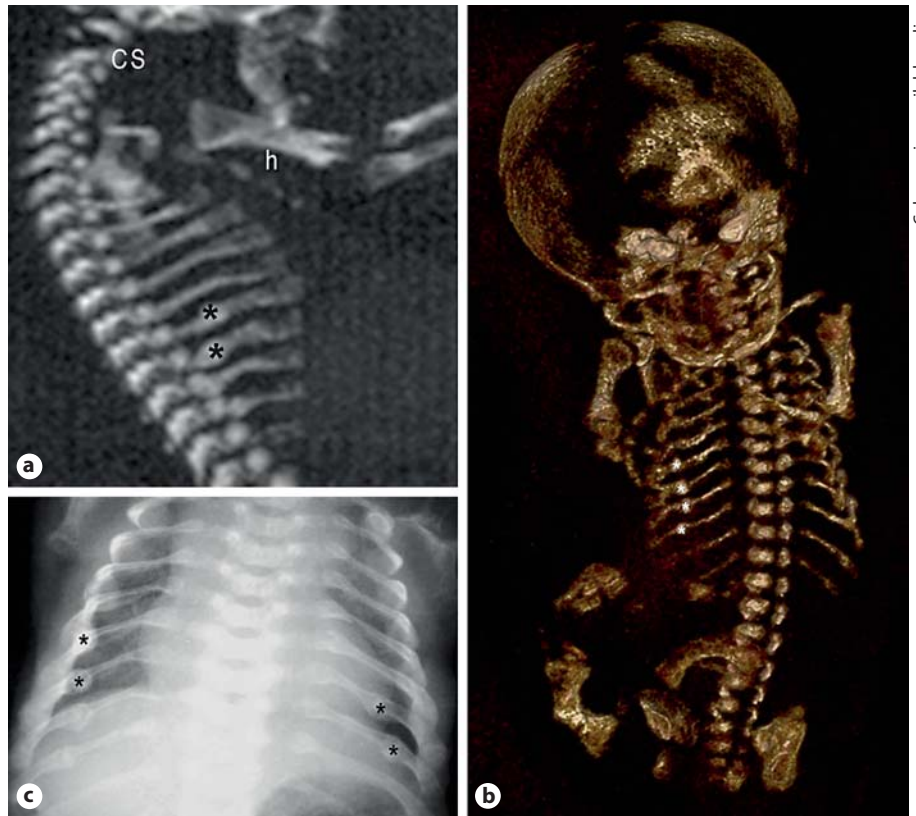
Case 2: osteogenesis imperfecta type II. a 3D-CT MIP reconstruction of the fetal thorax (sagittal view). h = Humerus; CS = cervical spine. b 3D-CT coronal reconstruction of the entire fetus showing multiple irregular ribs with fractures (*). c Postnatal chest X-ray confirming bilateral fractures of ribs (*).
